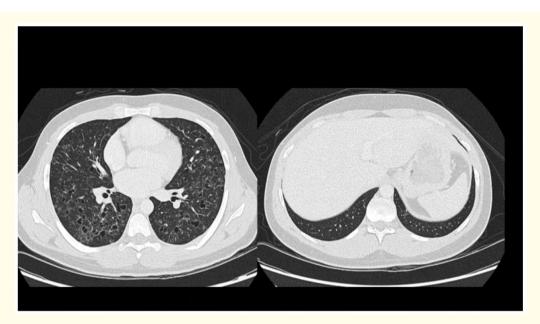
HRCT axial scans on the same patient as in figure 1: Show a combination of cysts, lung parenchymal undergo fibrosis and a honeycomb pattern. HRCT plays a pivotal role in diagnosis/differential diagnosis of PLCH.
